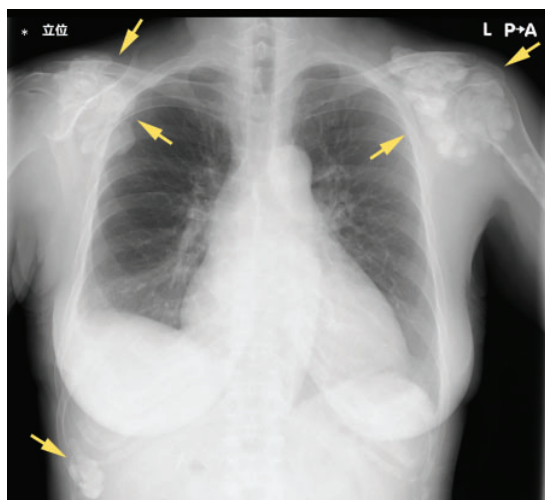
Chest radiography showed large, irregular, calcified masses (arrows) adjacent to the shoulders and beneath the right lower ribs.
